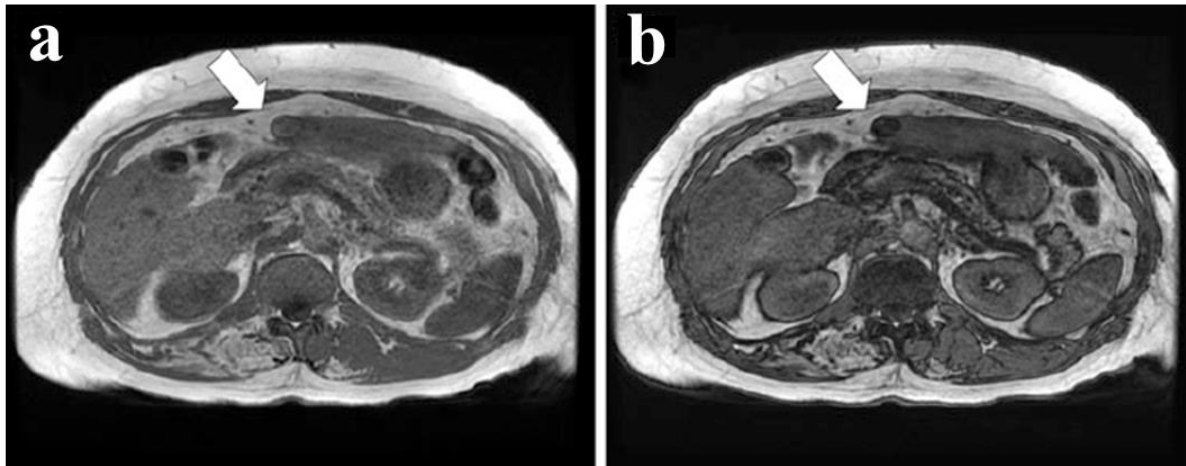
Axial IP (a) and OP (b) MRI images of patient showing focal HCC with fat content (arrows). IP shows HCC slightly iso-intense signal compared to the surrounding liver parenchyma (arrows). OP shows signal loss in HCC, indicating HCC with fat content [93]
